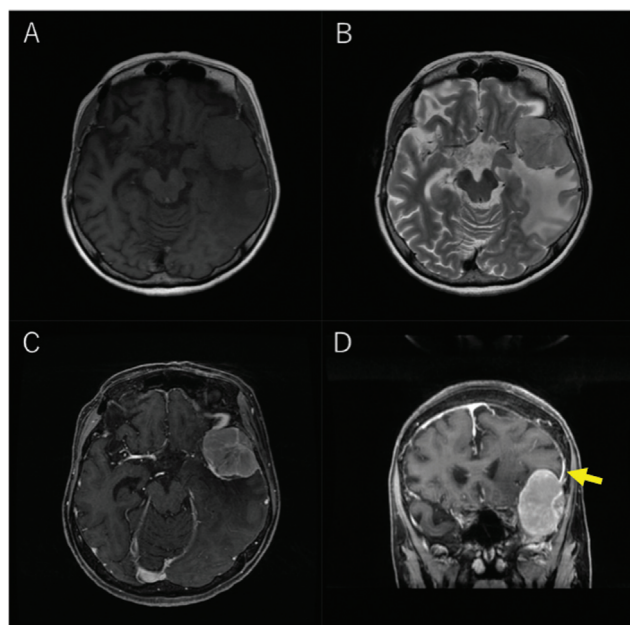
Preoperative magnetic resonance imaging. The preoperative T1-weighted image shows a well-defined, hypointense mass lesion in the left middle fossa (A). The T2-weighted image shows hyperintensity (B). The gadolinium-enhanced image shows an enhancement effect (C, axial section; D, coronal section). The dural tail sign was observed (D; arrow).
